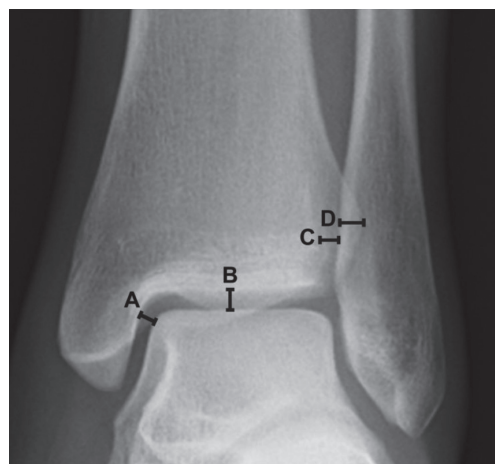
Radiographic parameters. A = TTCS, B = STTCS, C = TFCS, and D = TFOL.
